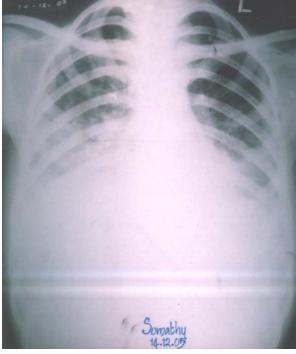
X-ray chest showing bilateral reticulonodular pattern
